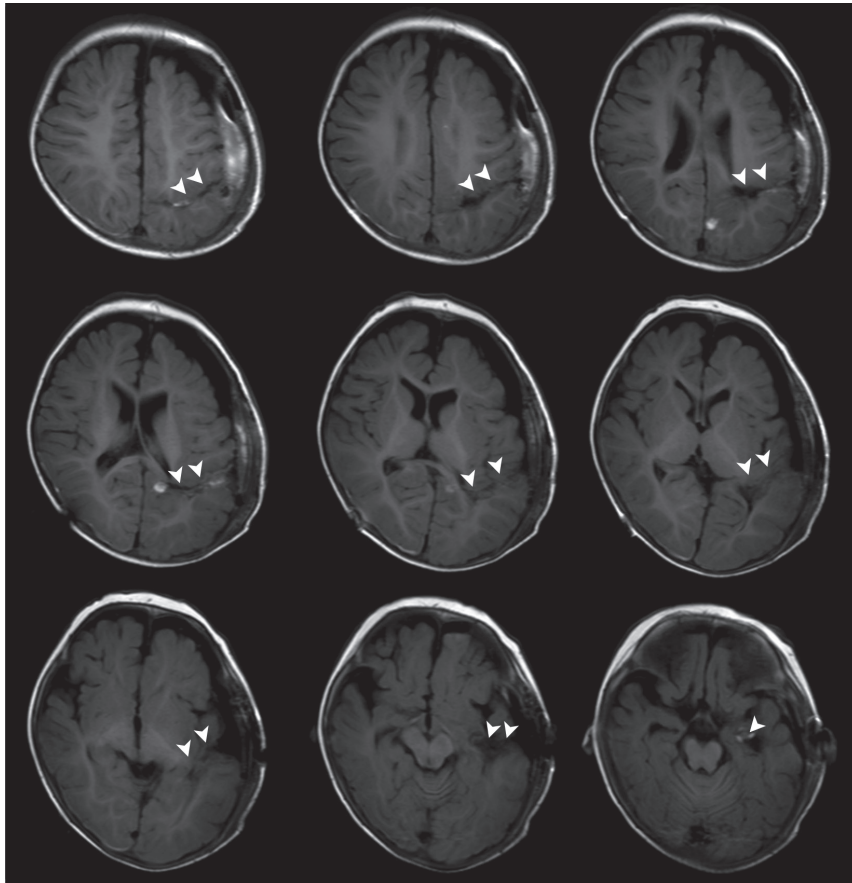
Magnetic resonance images of temporoparietooccipital disconnection (Patient PQ2). Arrow heads indicate the disconnection line.
